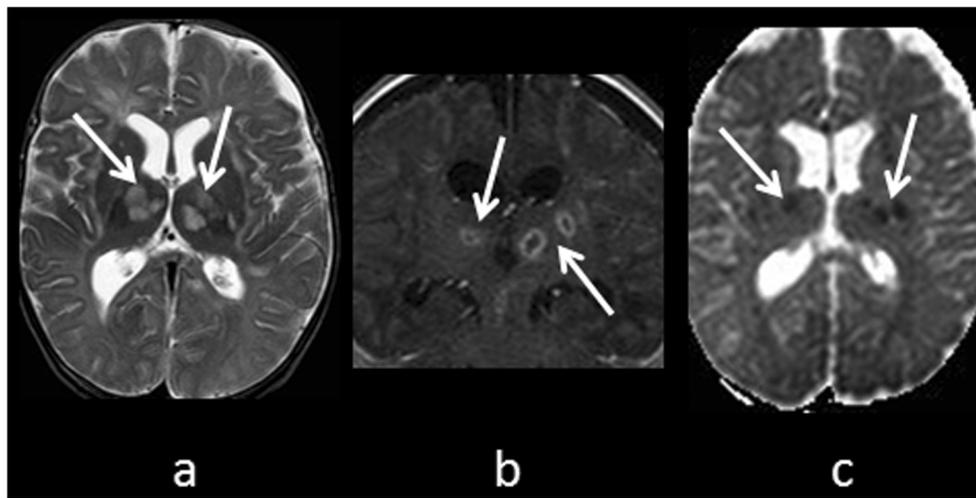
Brain abscesses from *beta-hemolytic streptococcus* infection. MR imaging study in a 13-day-old baby affected by multiple small brain abscesses from *beta-hemolytic streptococcus* infection. a Axial T2 and b coronal contrast enhanced T1-weighted sections showing multiple round shape lesions in basal ganglia region bilaterally, characterized by
